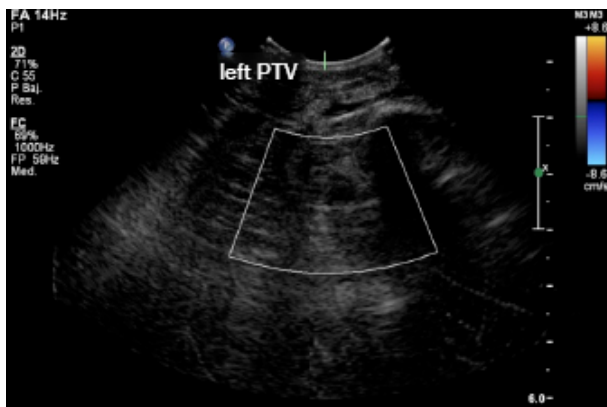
Doppler ultrasound: left posterior tibial vein (PTV) thrombosis. Source: Document obtained during the study.
